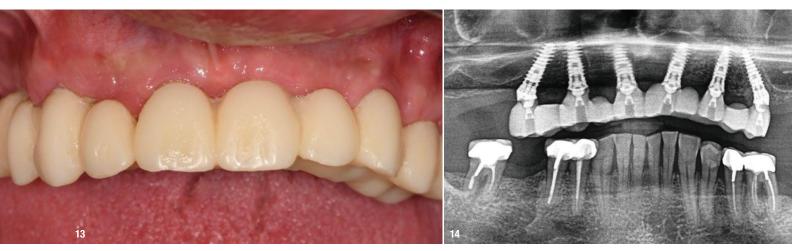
Clinical image three months postsurgery, showing healthy soft tissue. Fig. 14: Radiograph three months postsurgery, demonstrating stable bone levels.
